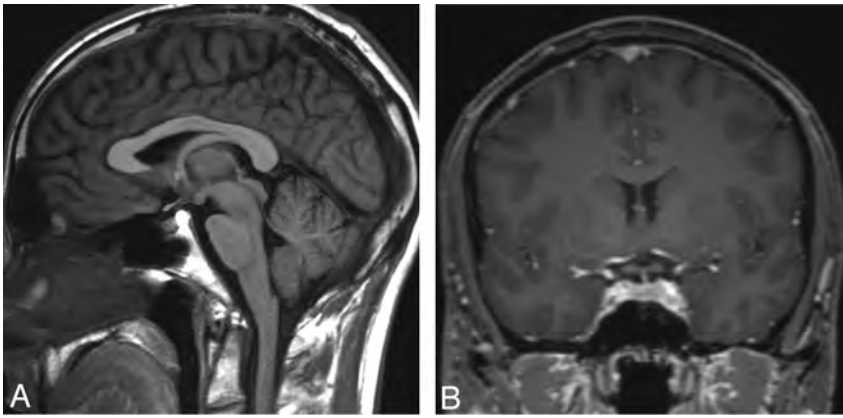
A, Sagittal T1-weighted MR image 6 weeks after treatment shows an image of the brain with normal findings. B, Coronal postcontrast T1-weighted MR image after treatment shows resolution of the diffuse pachymeningeal enhancement.
